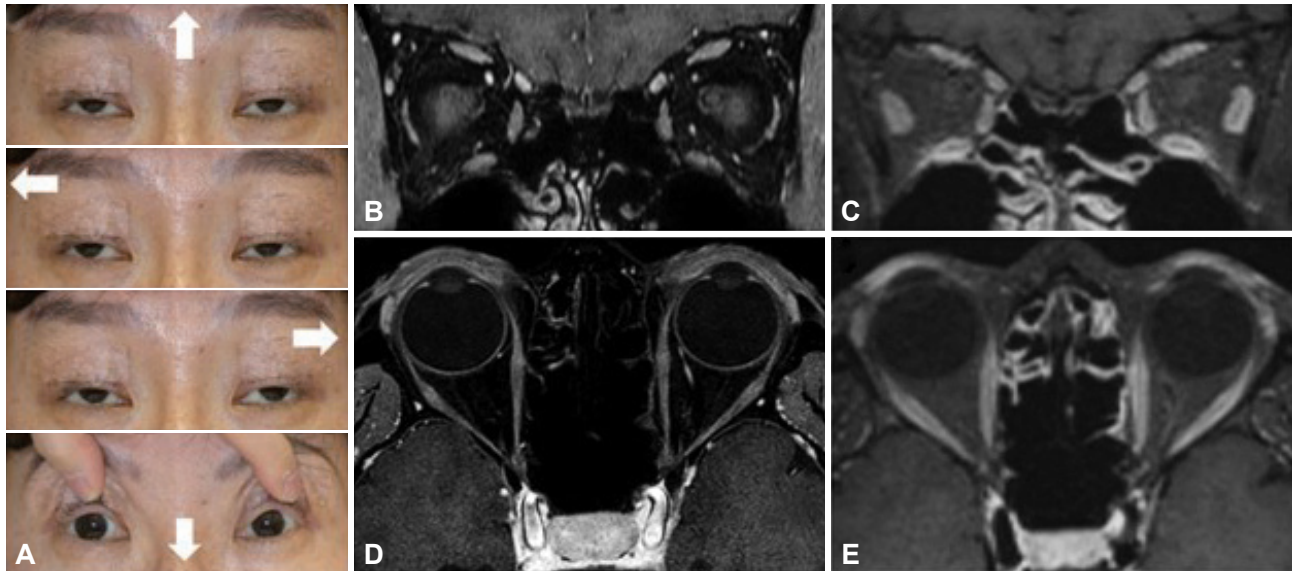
Clinical (A) and radiologic (B–E) features of the patient. A: The patient had severe extraocular muscle (EOM) limitations. The arrows show gaze directions. Coronal and axial contrast-enhanced fat-suppressed T1-weighted magnetic resonance images of the orbit show diffuse atrophy and heterogeneous enhancement of the EOMs (B and D, respectively), which was homogeneous at baseline (C and E, respectively).
